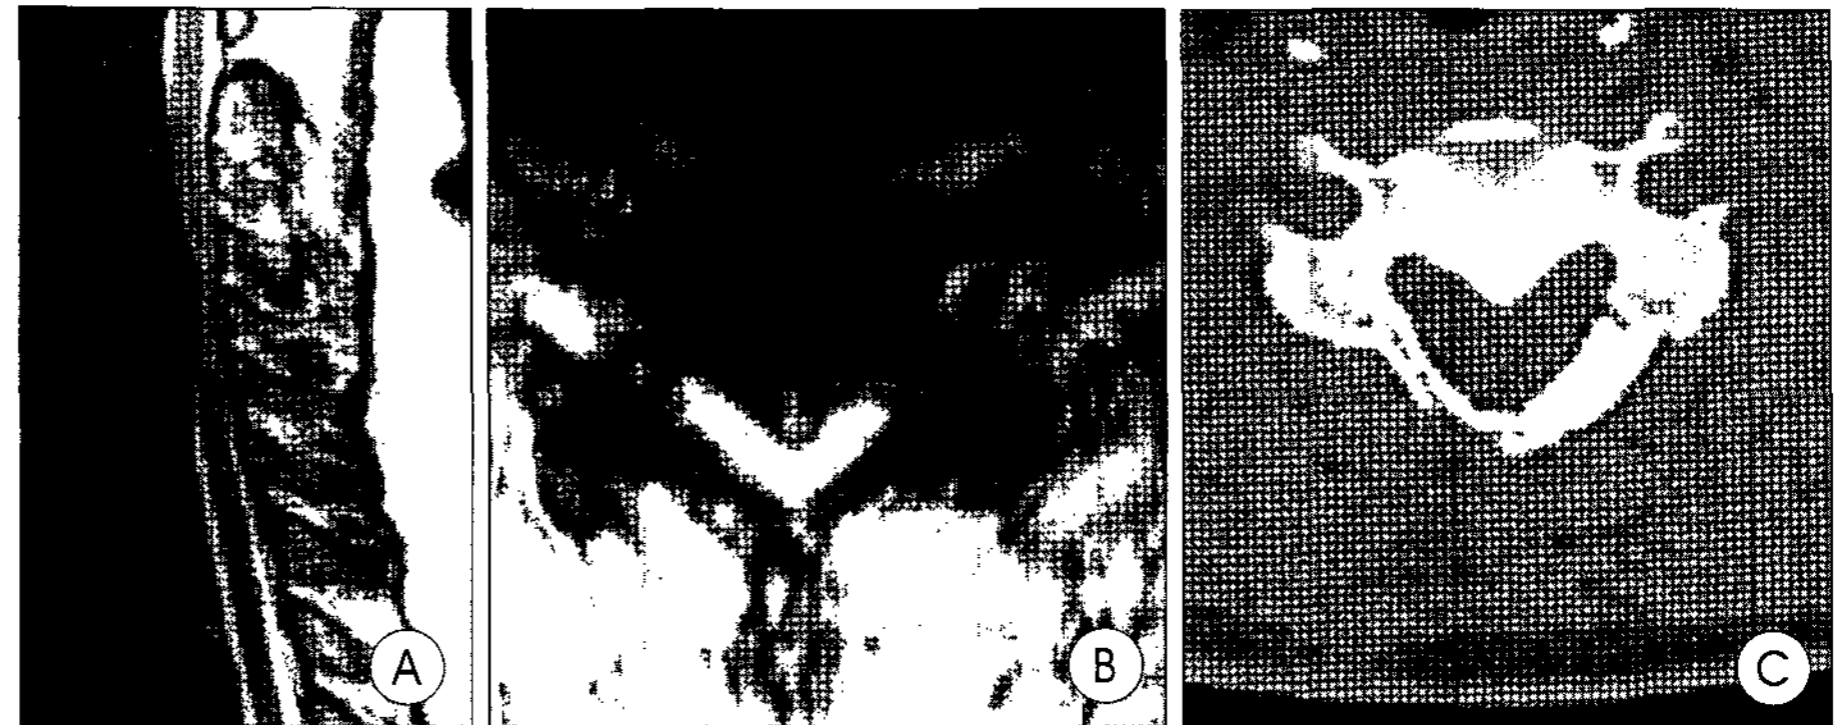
A, B : On preoperative T2-weighted magnetic resonance images showing continuous type ossification of posterior longitudinal ligament from C3 to C6. The anterior pressure on the spinal cord and dural sac is clearly seen from C3 to C6. C : Six months after the operation, computed tomography scan shows osseous union of the laminoplasty and the well-maintained, enlarged expansion of the spinal canal.
